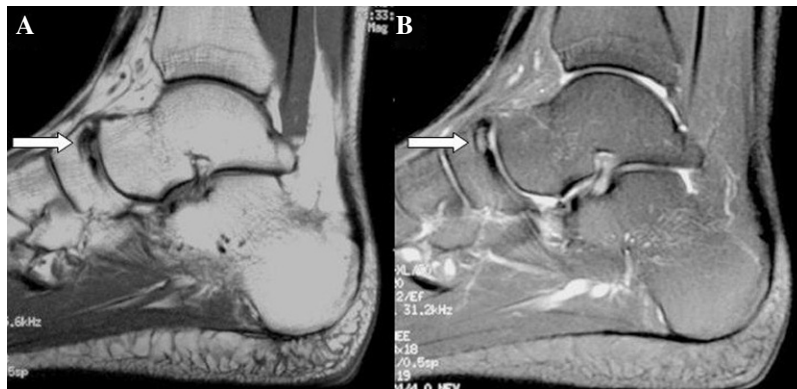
MRI of the tarsal navicular OCD in the sagittal plane. The osteochondral fragment (arrows) has low signal intensity on T1-weighted image (A) and high signal intensity on T2-weighted image (B).
